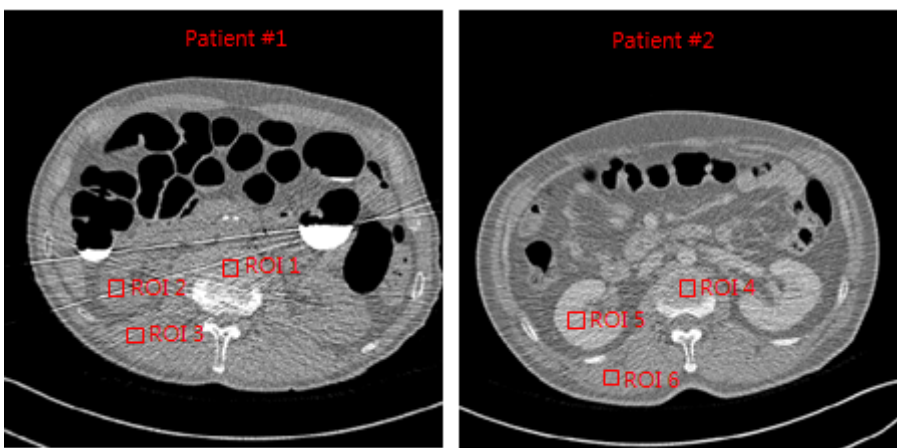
ROI marks on the CT images of patients with (patient #1) and without (patient #2) tagging material
